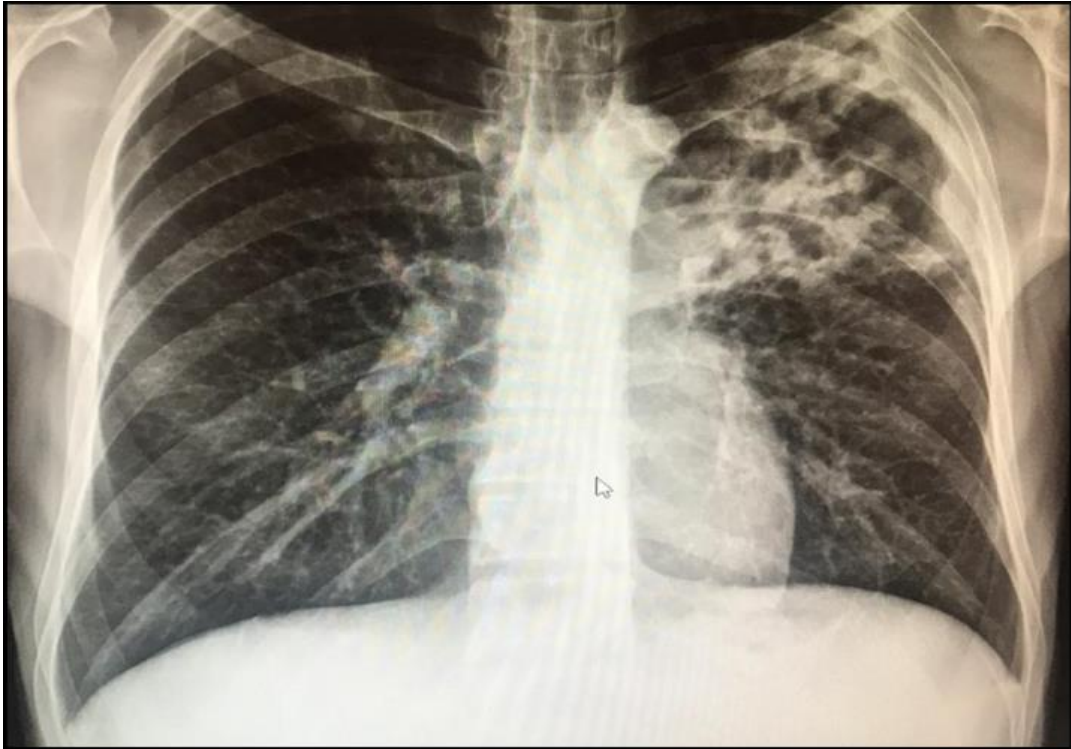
Chest X-ray (September 2017, Day 120) showing consolidation area in the left upper lobe, paraseptal thickening and bronchial thickening in the peripheral region.
